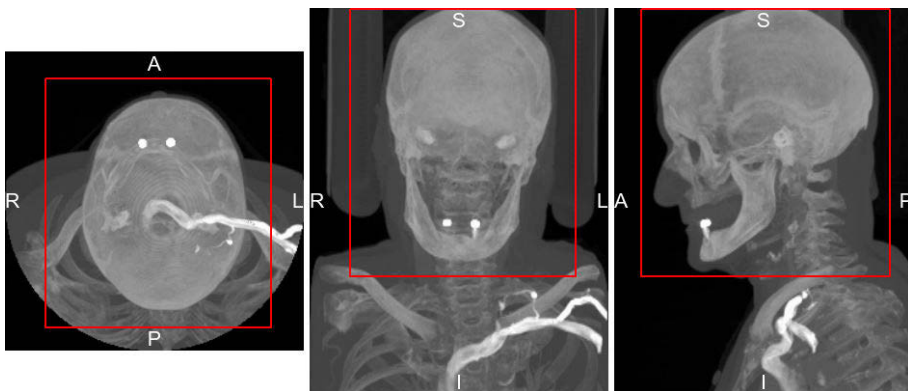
Interactive rectangle selection tool that allows the user to crop a CT image around the region of interest (ROI) in maximum intensity projection views.
